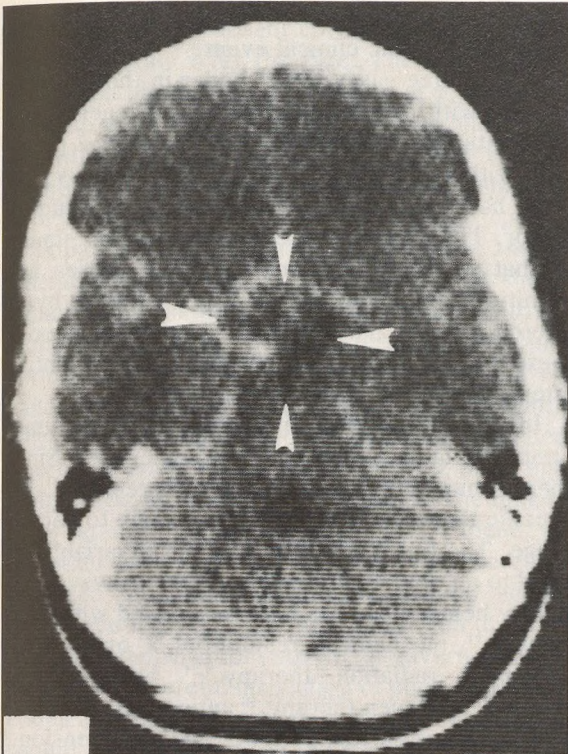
CT scan of the sella revealing mass lesion in an enlarged sella turcica (Case 1)
